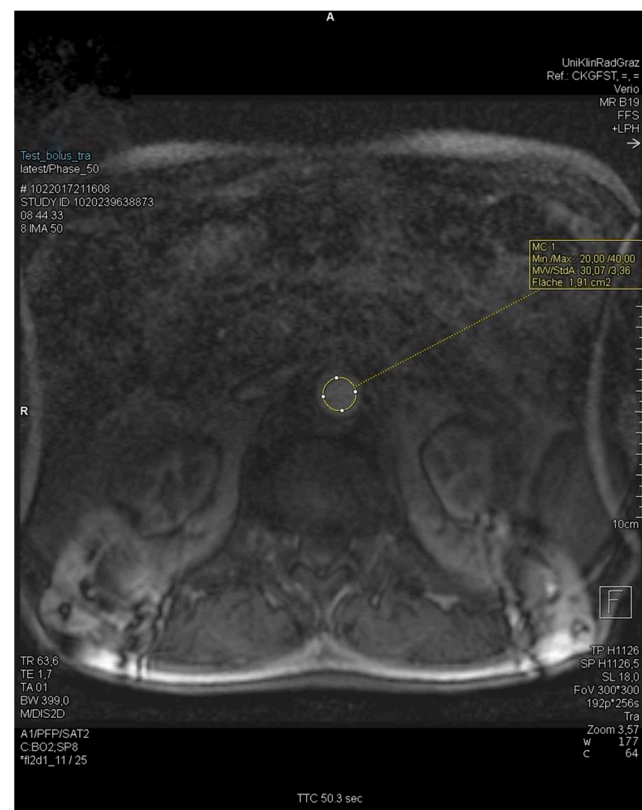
MRI of ROI set in the abdominal aorta at kidney level.
